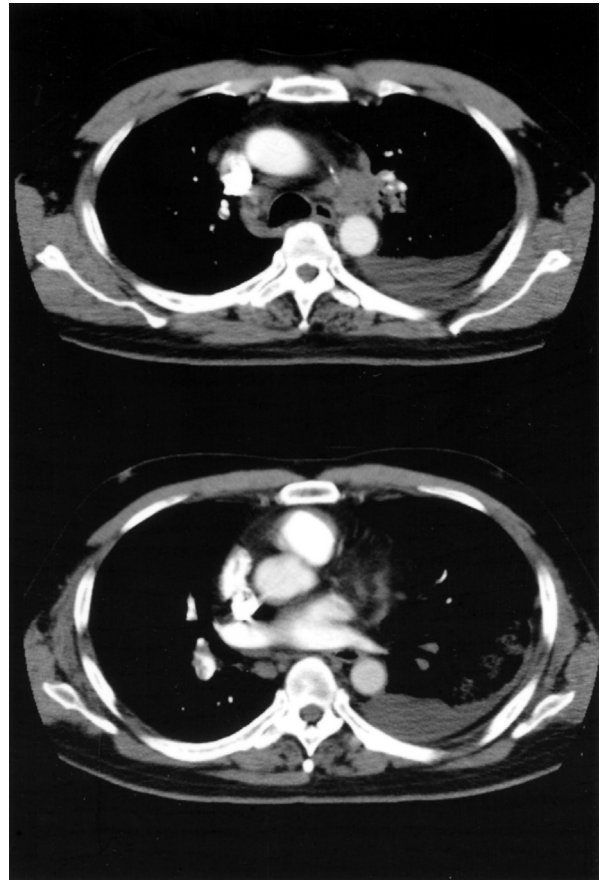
Chest computed tomographic scan with contrast showing subaortic tumor growth and multiple filling defects within segmental branches of the right-side pulmonary arteries, compatible with the pulmonary embolism diagnosis.
